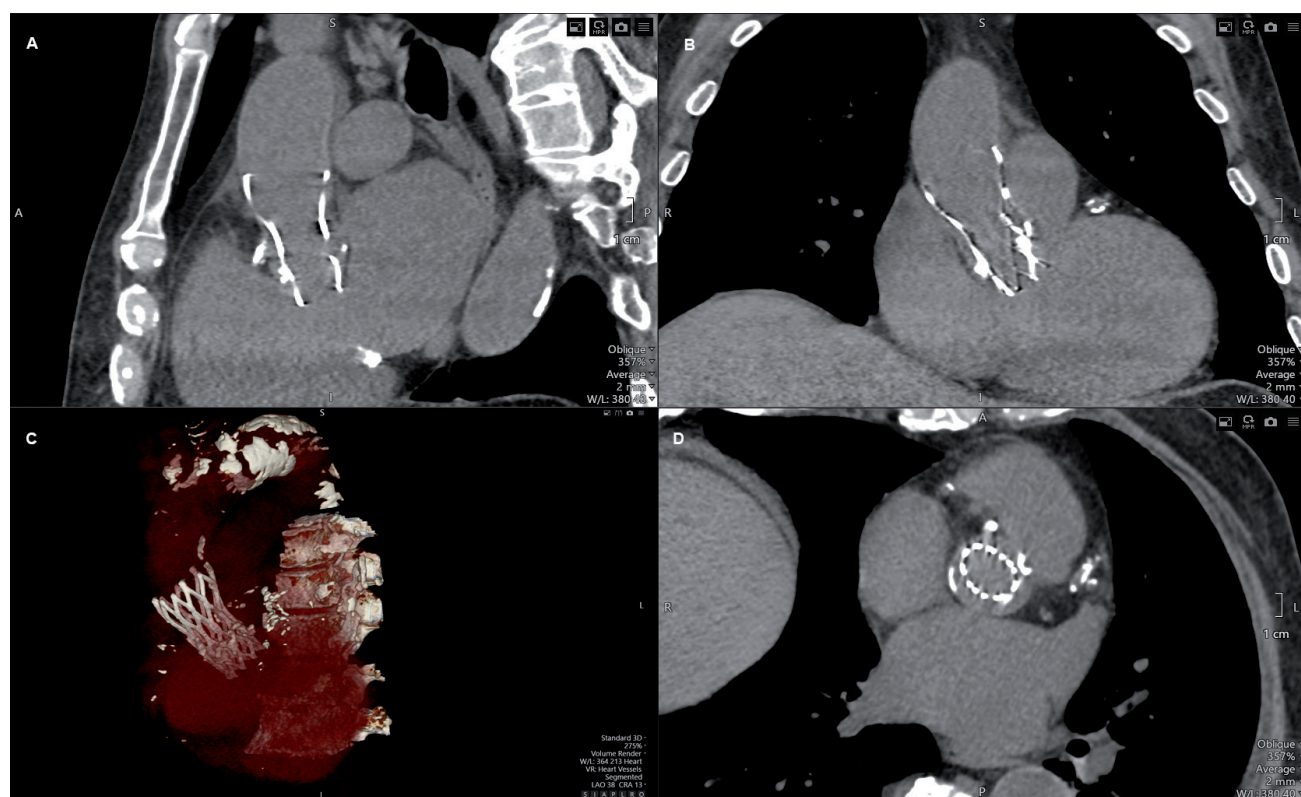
Cardiac computed tomography showing the transcatheter Portico valve frame deformation due to the presence of severe aortic annular calcifications in A: sagittal projection, B: coronal projection, C: 3D projection and D: axial projection
